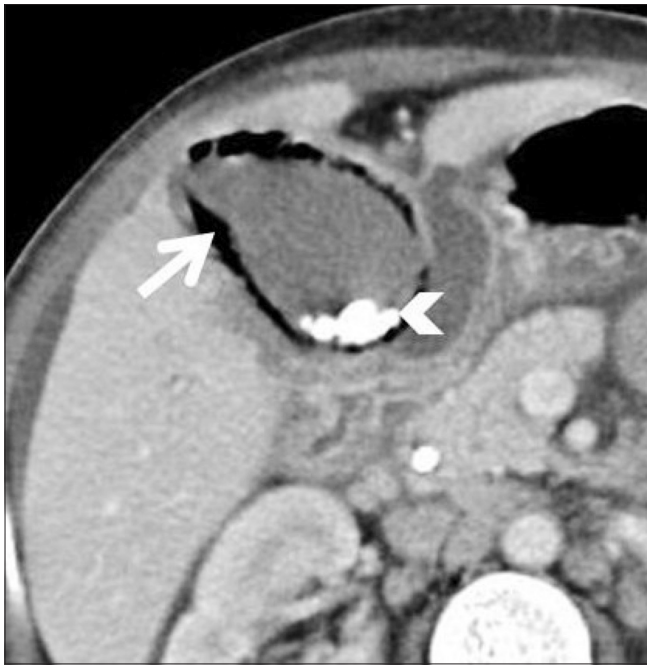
Axial CT scan shows intramural air in the gall bladder (arrow), with cholelithiasis (arrowhead)
